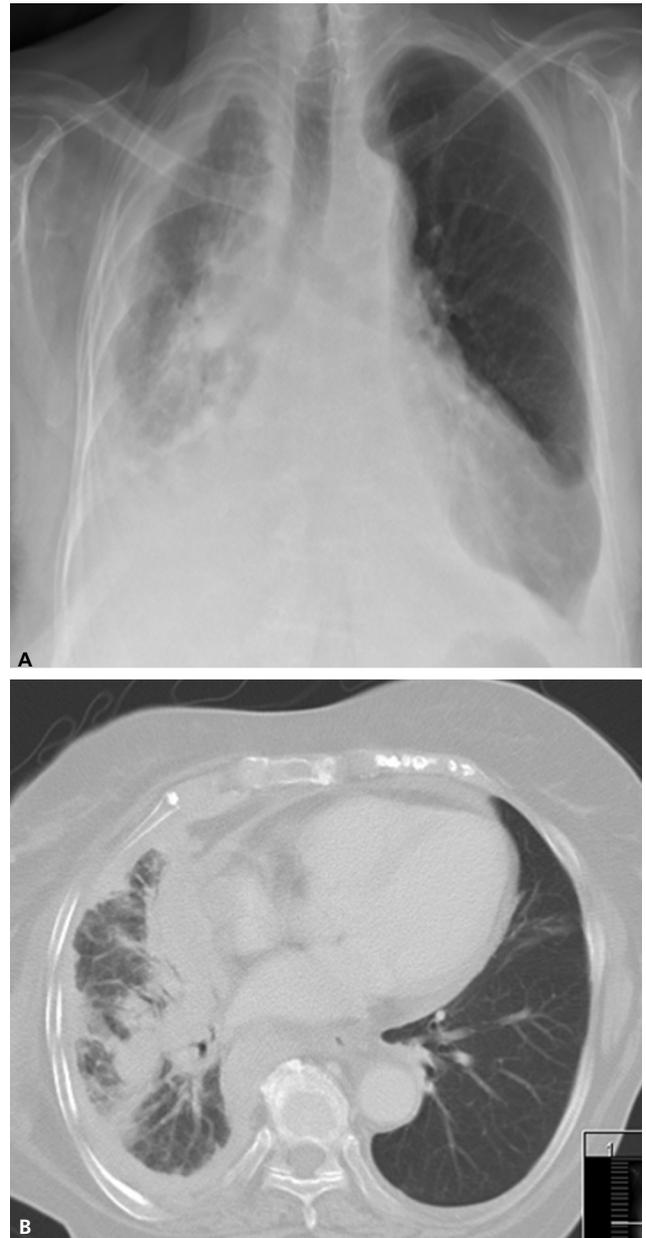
A right-sided pleural effusion and pleural thickening in posterior-anterior chest X-ray (A) and a massive pleural effusion with multiple pleural nodules in thorax CT (B).
